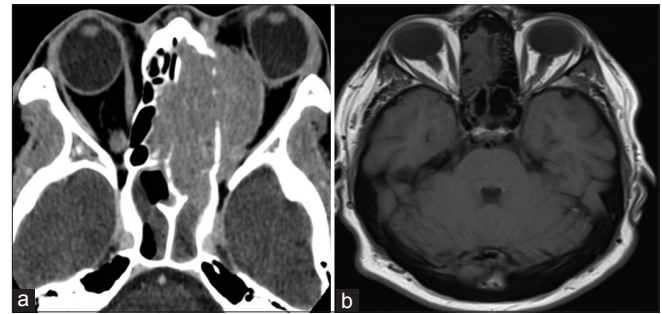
(a and b) Computed tomography and magnetic resonance imaging of Patient 3 and 4, respectively
